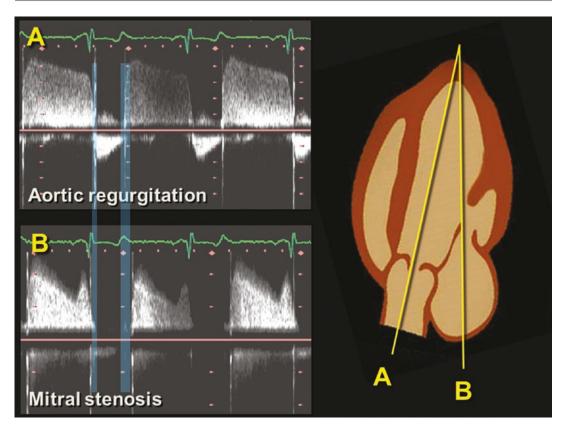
Continuous wave Doppler recordings from a patient with aortic regurgitation (top panel) and mitral stenosis (bottom panel). The light blue areas represent the periods of isovolumic relaxation and isovolumic contraction
